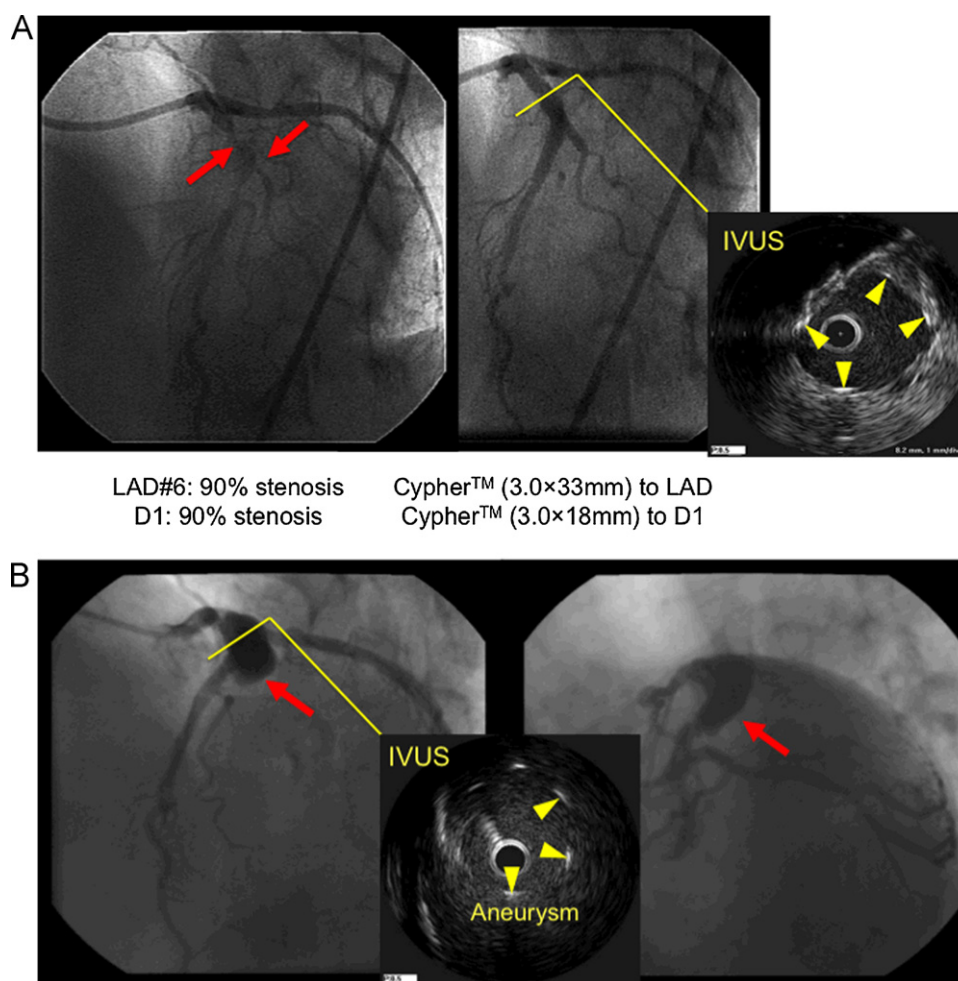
Coronary angiography and intravascular ultrasound (IVUS). (A) Coronary angiography revealed severe narrowings (arrows) at the proximal site of the left anterior descending artery (LAD) and at the first diagonal branch (D1) (left panel). Percutaneous coronary intervention to the LAD and D1 narrowings was performed with sirolimus-eluting stents (Cypher™) implantation (right panel). IVUS revealed complete stent strut apposition at the stented site of the LAD. Arrow heads indicate stent strut. (B) Three years after acute myocardial infarction, coronary angiography revealed giant coronary artery aneurysm formation (arrows) at the stented site of the LAD with total occlusion of the D1. IVUS revealed stent malapposition and a giant aneurysm formation at the stented site of the LAD. Arrow heads indicate stent strut.
